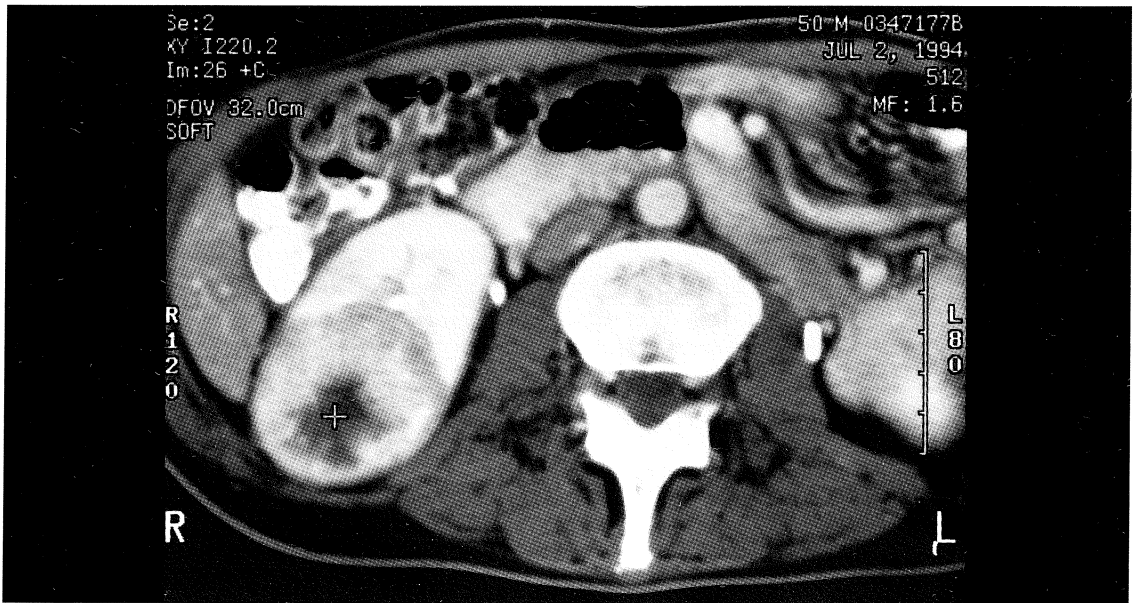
Contrast-enhanced CT scan of the kidneys.
